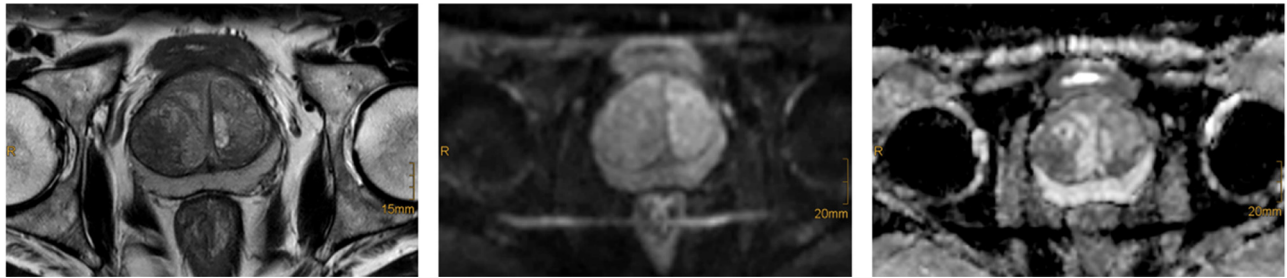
MR-images of prostatitis. Left: Transversal T2-weighted image with indistinct hypointensity in the right transitional zone. Middle: Transversal diffusion weighted image (DWI) with isointensity in the right transitional zone on b-800 images. Right: Hypointensity in the right transitional zone in the apparent diffusion coefficient (ADC) map.
